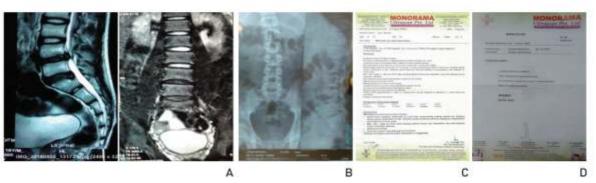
MRI and X-Ray findings after administration of homeopathic medicine.
